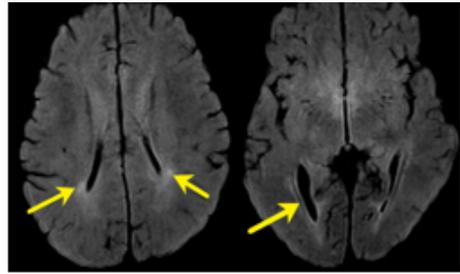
Axial FLAIR images of a 12yr old female with complaints cognitive disabilities shows prominence of occipital horns of bilateral lateral ventricles with periventricular hyperintense signal.
